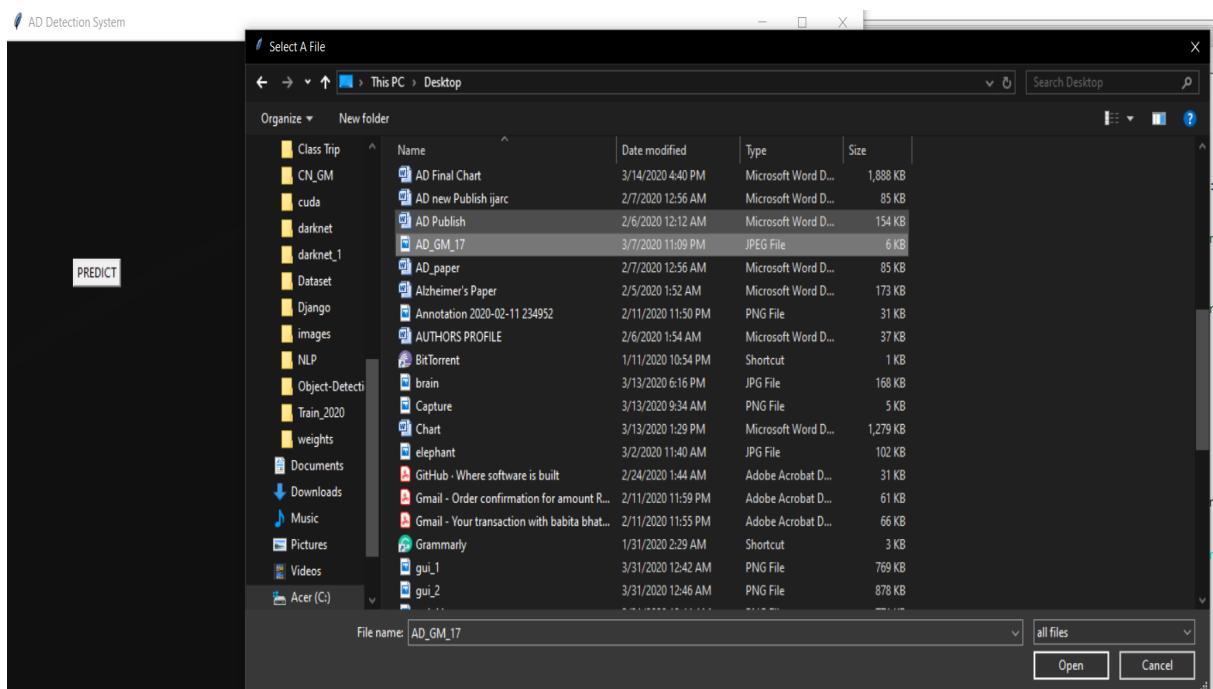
Uploading an MRI Scan Image
